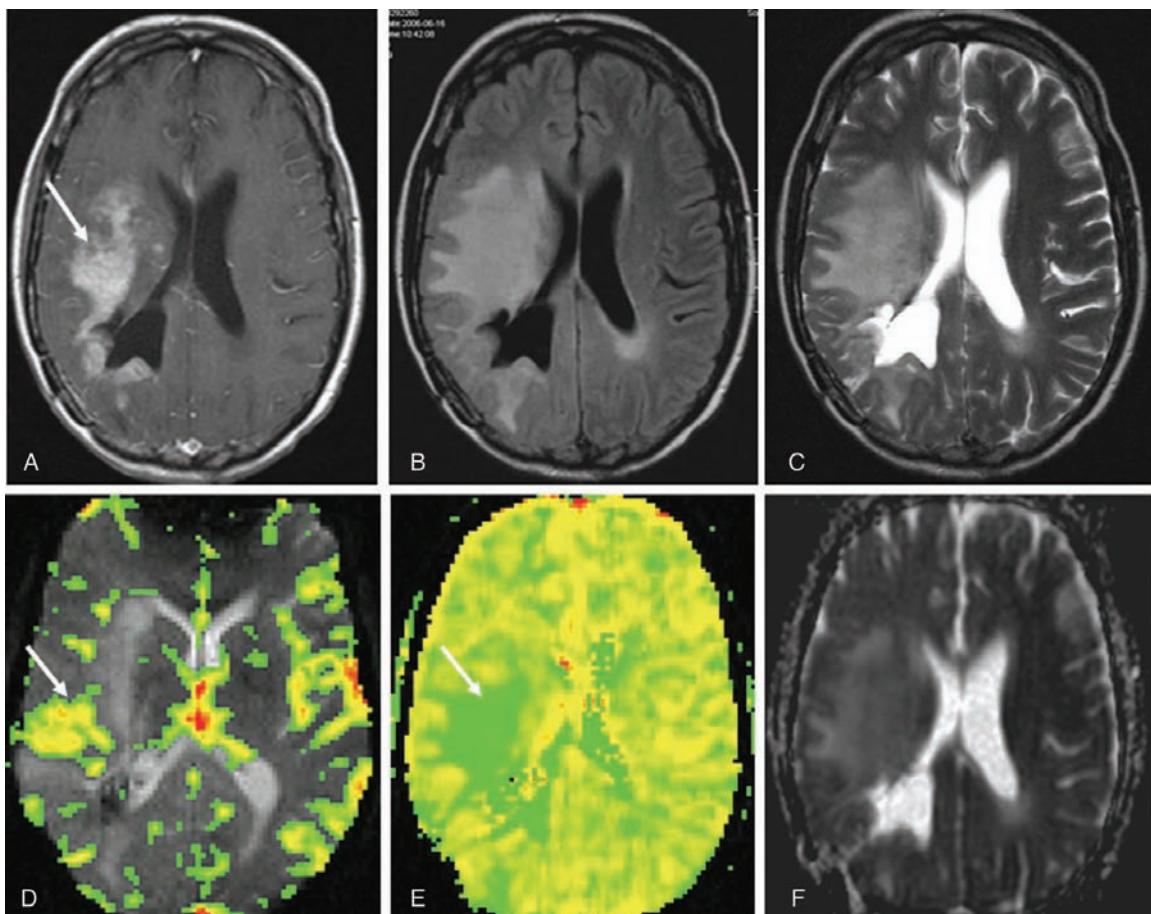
Pathologically recurrent glioblastoma multiforme (WHO grade IV). (A) Axial T1-weighted post-gadolinium image. (B/C) Axial FLAIR and T2-weighted images demonstrating recurrent enhancing glioma in the right frontoparietal region (white arrow). There is also substantial associated T2 signal abnormality with mass effect on the right lateral ventricle. (D) Gradient-echo axial DSC MRI with rCBV color overlay demonstrates high rCBV within the lesion (white arrow). (E) Gradient-echo axial DSC MRI with SD25 color overlay depicts signal intensity drop after 25 seconds indicating increased vascular permeability (white arrow). (F) Diffusion-weighted ADC image demonstrates some decrease in signal in keeping with some tumor cellularity within the recurrent glioma. Abbreviations: FLAIR, fast fluid-attenuated inversion recovery; DSC MRI, dynamic susceptibility contrast MRI; ADC, apparent diffusion coefficient.
